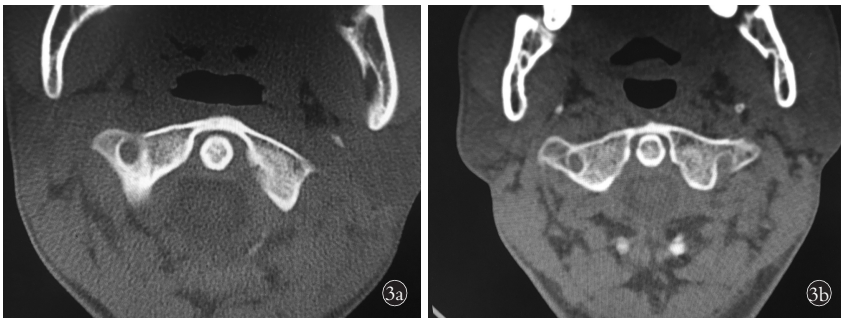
男性患者,18 岁,外伤致寰枢椎关节半脱位 3a. 治疗前 CT 示寰枢椎间隙不对称,右侧约 3 mm,左侧约 5 mm 3b. 经过 2 个疗程的牵引治疗后复查 CT 示寰枢椎间隙左右对称,疼痛缓解,活动自如
